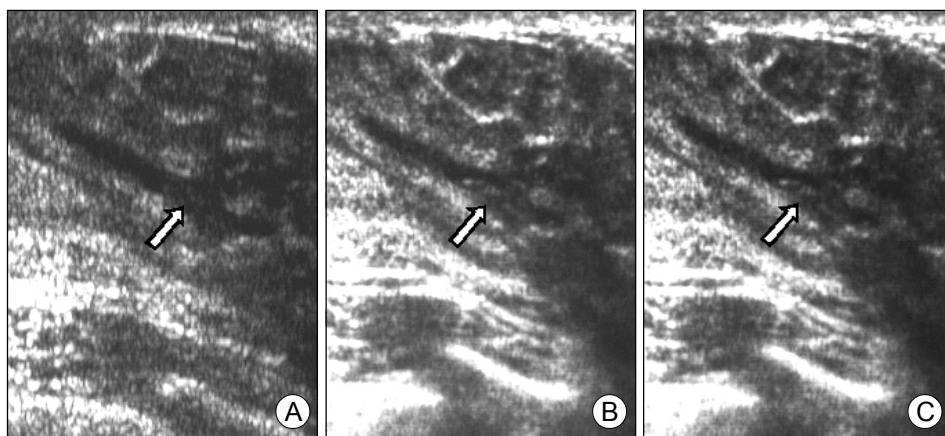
33-year-old female with ductal carcinoma in situ. Ultrasonograms show a circumscribed oval shaped isoechoic intraductal nodule (arrows) in subareolar area. Survey (B) and target (C) modes of RTCI are superior to CI (A) for evaluation of the margin and internal echoes of nodule.
